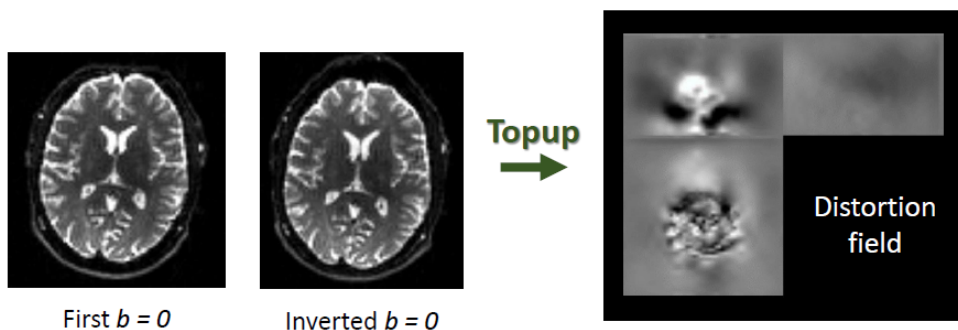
Example of the two $b = 0$ DWI images (left) used to construct the distortion field (right) during *Top Up* correction.
